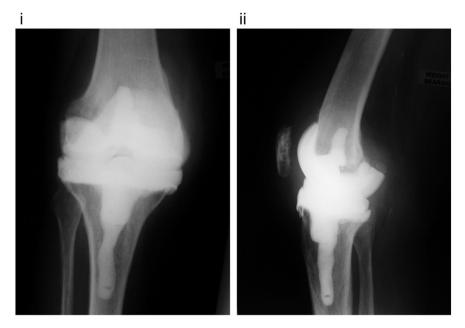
i: AP radiograph of cemented articulated spacer in situ. ii: Lateral radiograph of cemented articulated spacer in situ.
